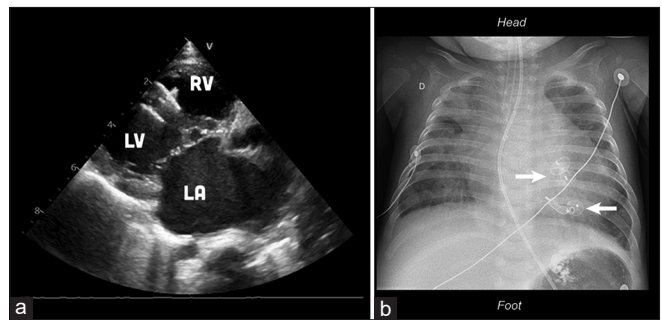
Two-year follow-up echocardiography (a) and thoracic chest X-ray (b) showing Konar-MF™ devices apposition with no residual shunt. LA: Left atrium, LV: Left ventricle, RV: Right ventricle
